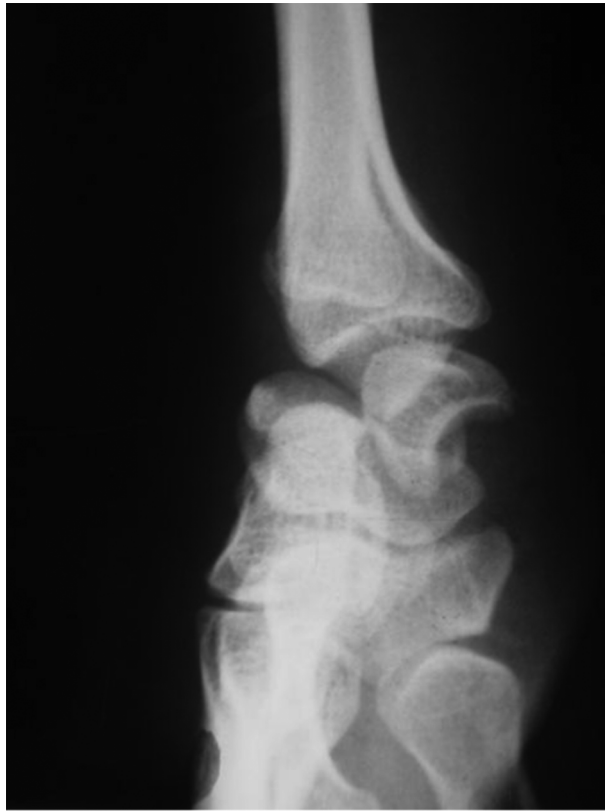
Wrist Radiographs
